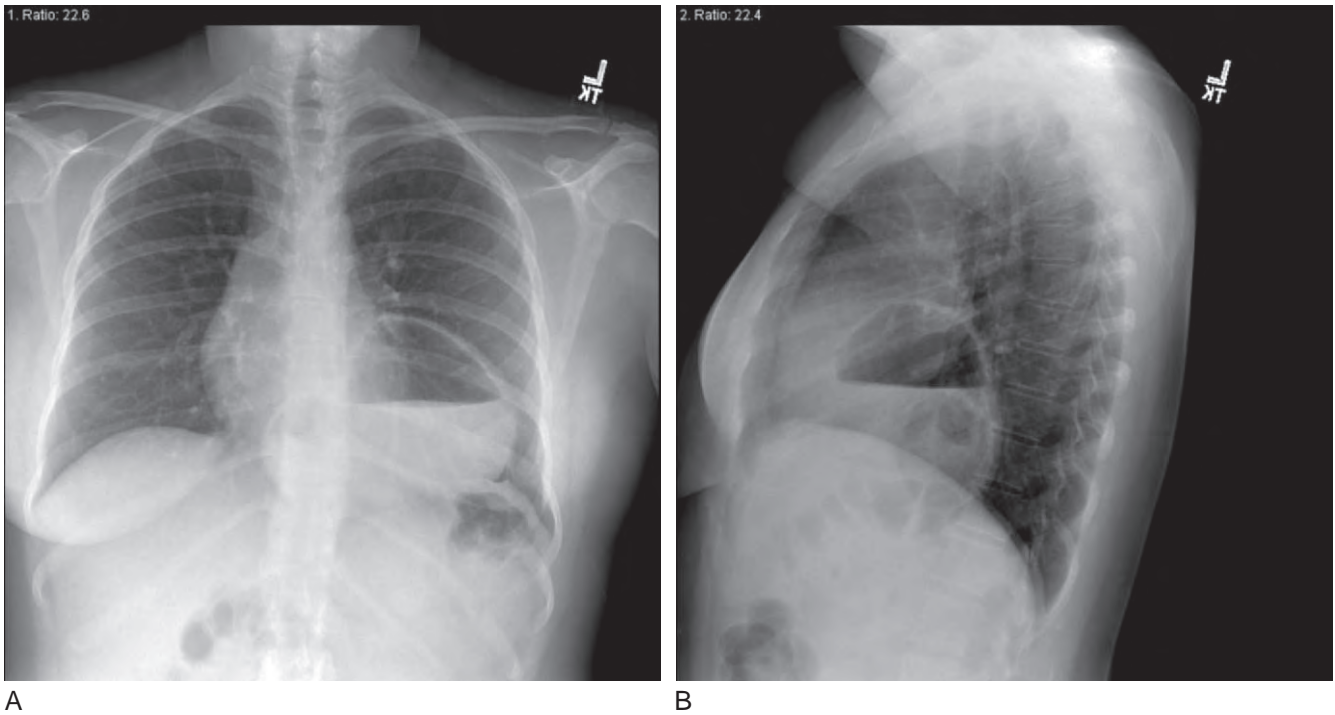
Posteroanterior (A) and lateral (B) chest radiographs in a patient with a paraesophageal hernia. Notice the large air-fluid level behind the cardiac silhouette as a result of the intrathoracic stomach.
